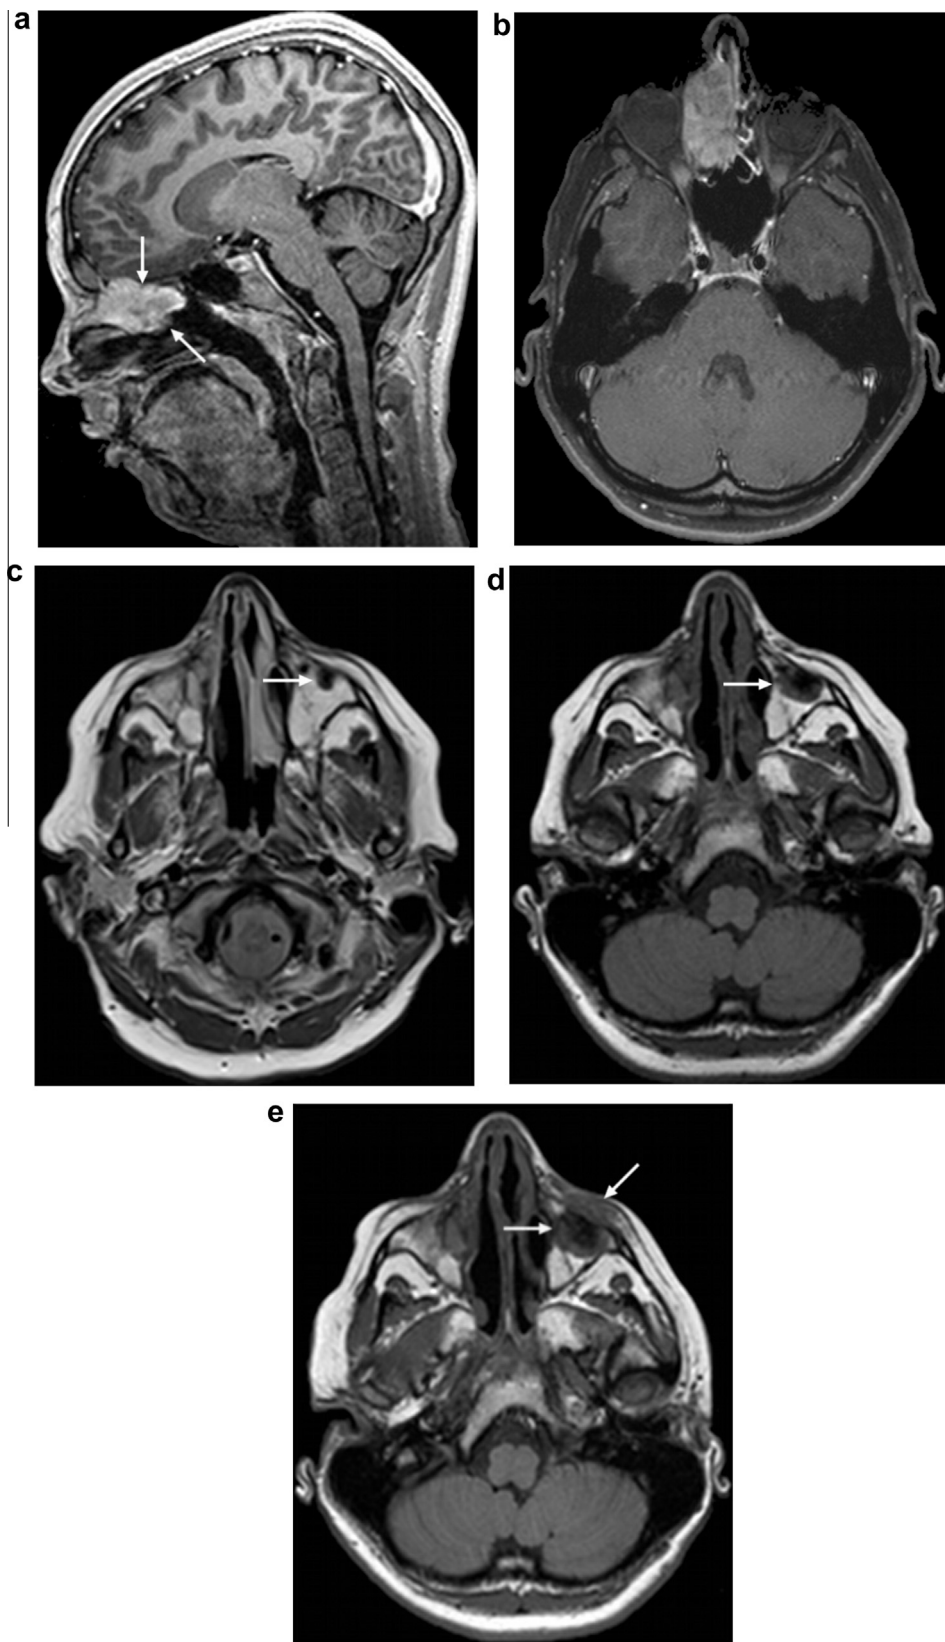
A 13-year-old girl presenting with a second and third primary tumour after bilateral EBRT at 2 months of age. An embryonal rhabdomyosarcoma of the right ethmoid sinus (a and b) occurred at 13 years of age, which was treated with chemotherapy, surgery and brachytherapy. During follow-up for this second primary tumour, the patient complained about a painful swelling under the left eye and magnetic resonance imaging (MRI) demonstrated an osteosarcoma originating from the orbital floor with soft-tissue invasion (small arrow) (e). Retrospectively, this tumour could be observed 6 months and 2 months earlier without soft-tissue invasion (c and d). This third primary tumour was treated with chemotherapy, extensive surgery and brachytherapy. Both tumours were completely resected and this girl is still in second complete remission.
